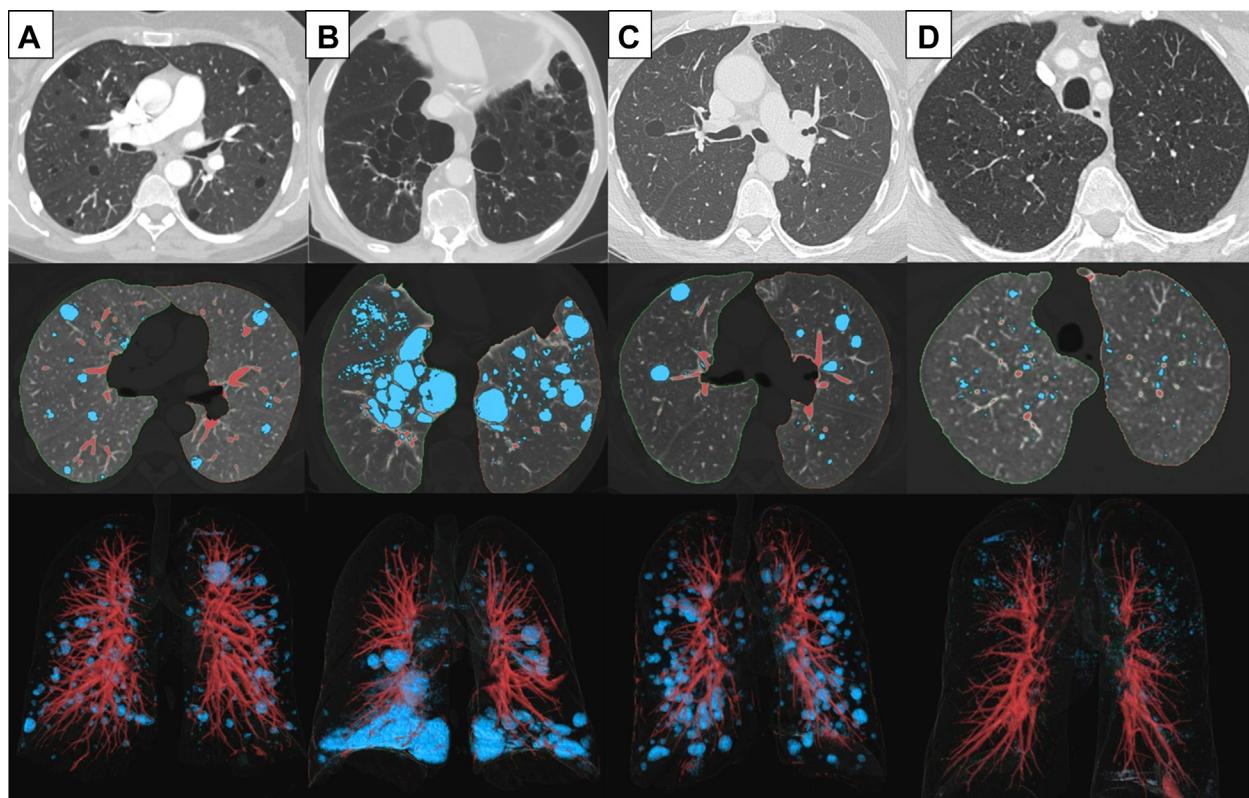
A-D, Cyst distribution in diffuse cystic lung diseases. CT thorax imaging showing cysts (in blue) in (A) lymphangioleiomyomatosis (LAM), (B) Birt-Hogg-Dubé syndrome (BHD), (C) lymphoid interstitial pneumonia (LIP), and (D) pulmonary Langerhans histiocytosis (PLCH). Notice the uniform distribution in LAM; subpleural, lower-lobe predominance of elliptical cysts in BHD; perivascular cysts in LIP; and upper lobe predominant cysts in PLCH.
